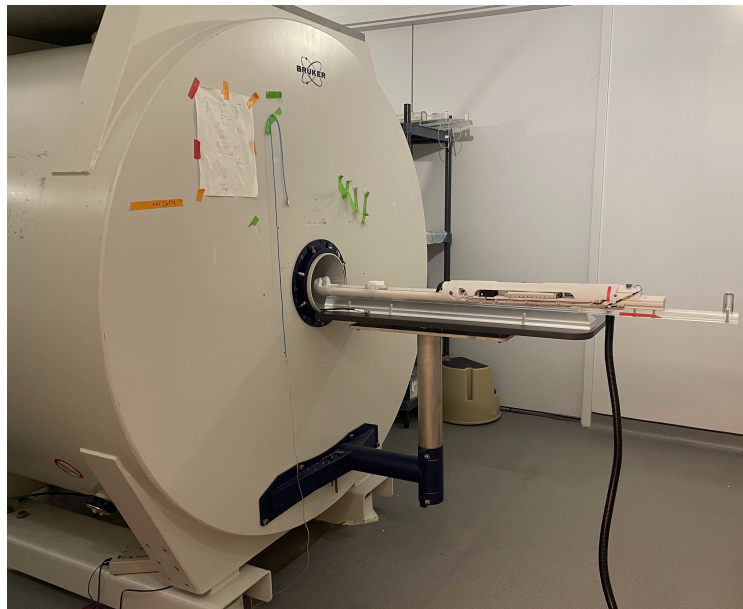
The RK-300 is designed to slide securely and safely into an MRI with butterfly adapter.
